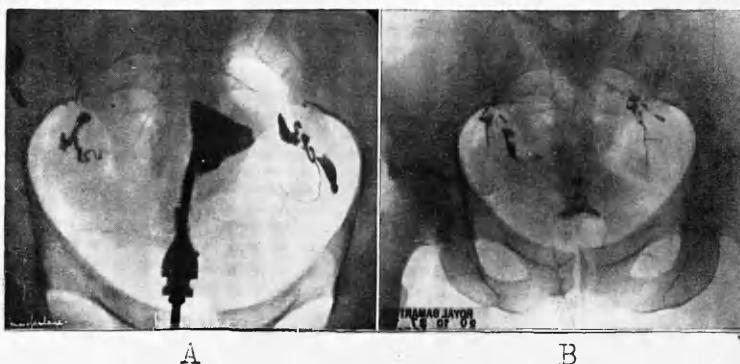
A. Normal bilateral patency. The triangular cavity of the uterus is larger than usual. B. Later radiograph in same case showing free lipiodol in the pelvis. Kymographic insufflation demonstrated normal peristalsis and patency at pressures of about 80 mm. Hg.
